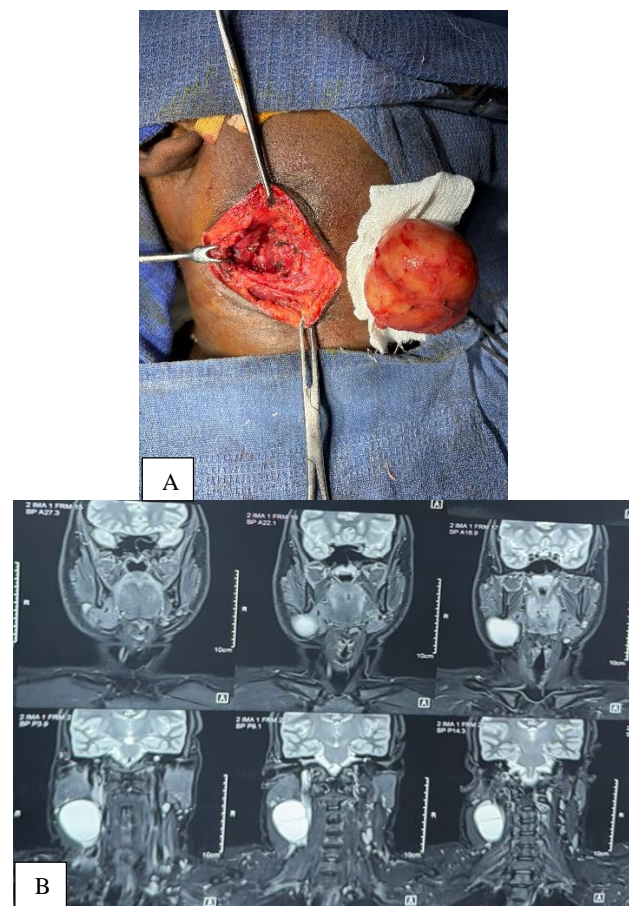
(A and B): CT showing a 3rd branchial cleft cyst. Intra-operative image of the excised swelling and the neck after dissection.
